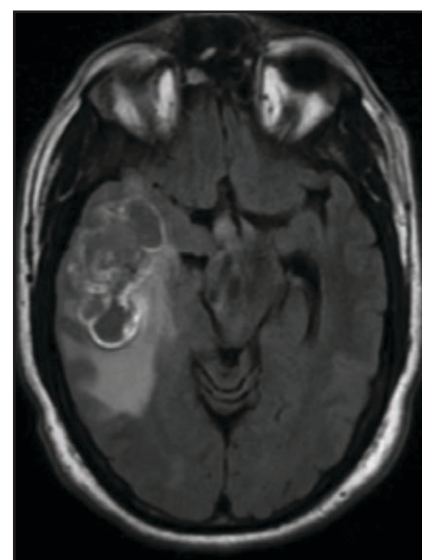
Preoperative T1-weighted cranial MRI. The lesion was accompanied by a midline shift, a leftward subfalcine herniation and an uncus herniation. Functional MRI revealed language localization of the left, and the mass to be separated from the motor strip.
